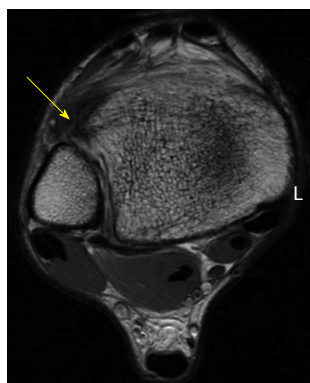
Axial fast-spin echo proton density magnetic resonance images of the right ankle seen in Figures 1 and 2. Disruption and remodeling of the anterior inferior tibiofibular ligament (yellow arrow) can be appreciated.
